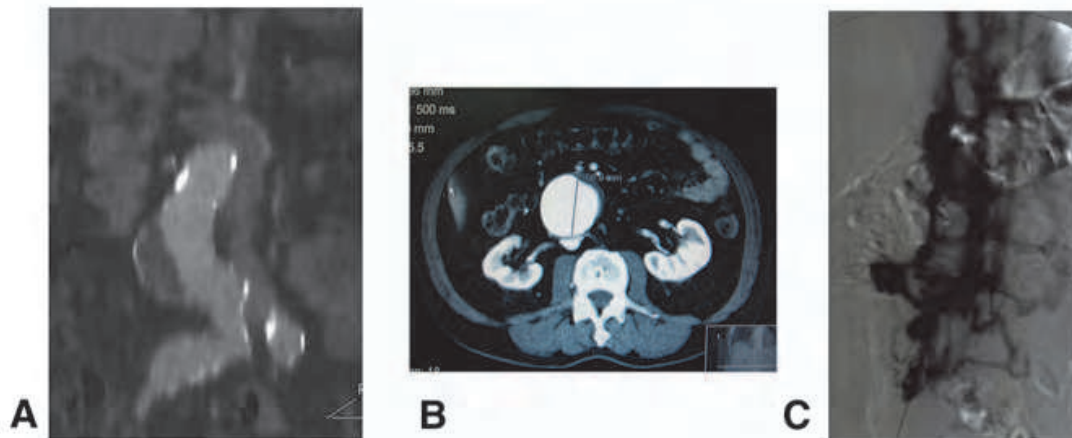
Inferior vena cava (IVC) anomalies CT and arteriography. A, Left IVC. B, Posterior IVC. C, Agenesis of IVC.
